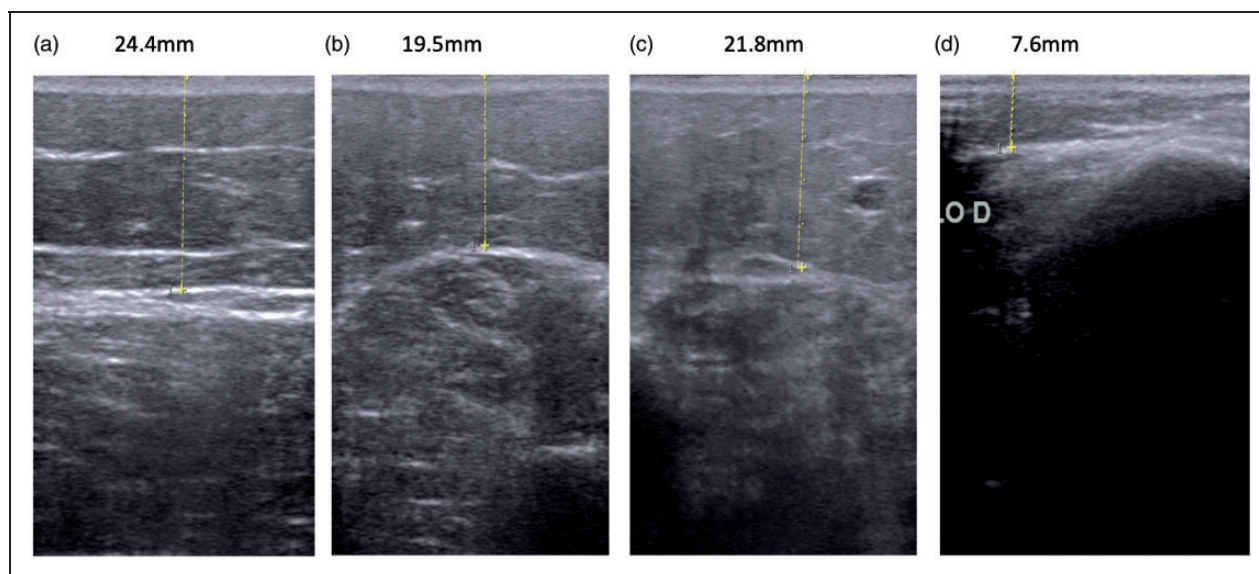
Ultrasound measurements with digital skin and subcutaneous ruler in a patient with clinically diagnosed lipedema. (a) Right thigh; (b) right lateral leg; (c) right pretibial; (d) right malleolus.
